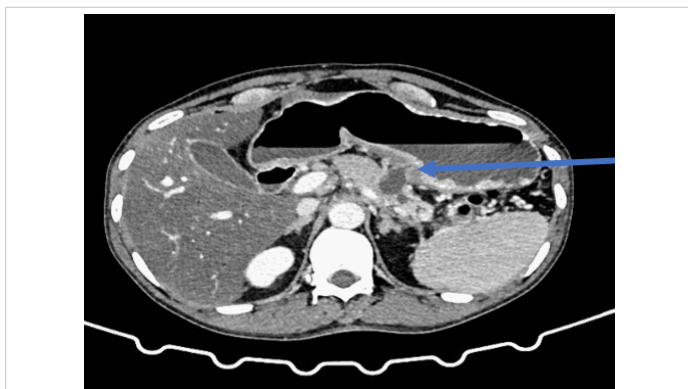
CT image showing fistula from cystic lesion in the pancreas to the stomach.
